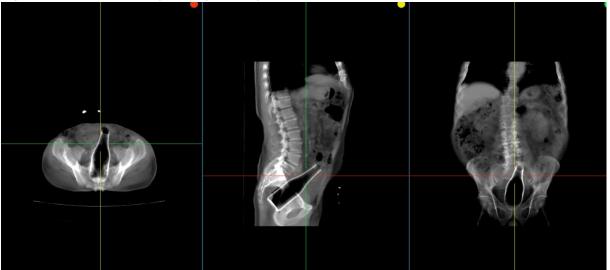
The image of the entire bottle was obtained after minimum intensity projection (MinIP) on axial, sagittal and coronal CT reformats.
